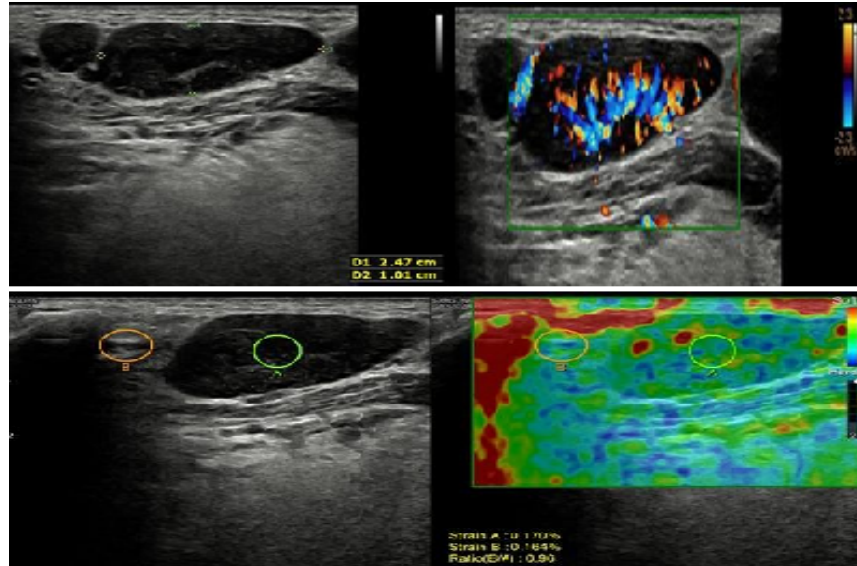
On grey scale USG, the lymph node is oval in shape with preserved fatty hilum showing a hilar pattern of vascularity on Color Doppler study. On elastography, the lymph node has elastography pattern 2 and SR of 0.96.
